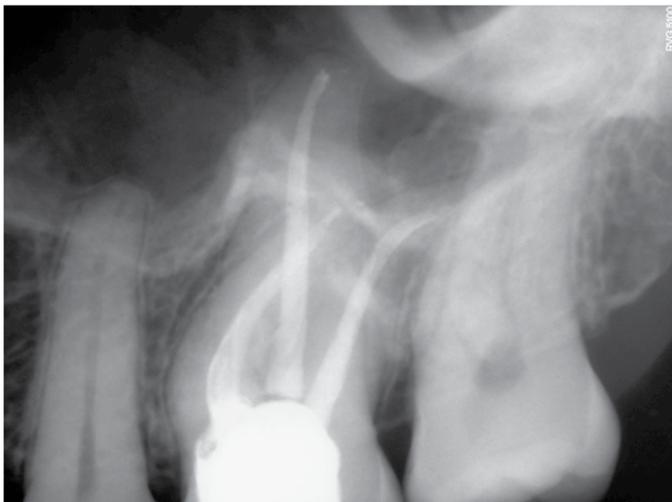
Postoperative intraoral digital periapical radiography.
